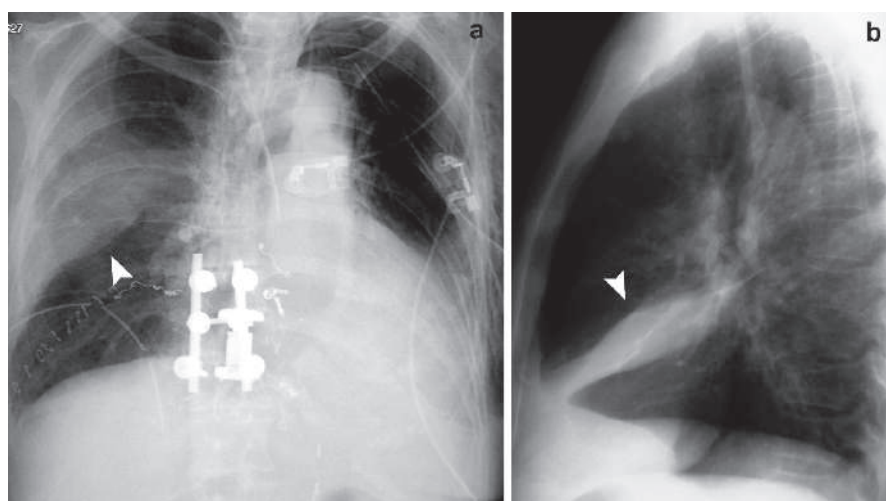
Posteroanterior (a) and lateral (b) chest radiographs show right-sided encysted pleural effusion (arrowheads)
